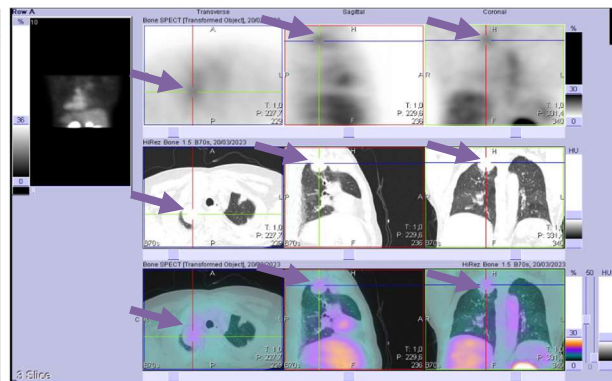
SPECT/CT Results.
